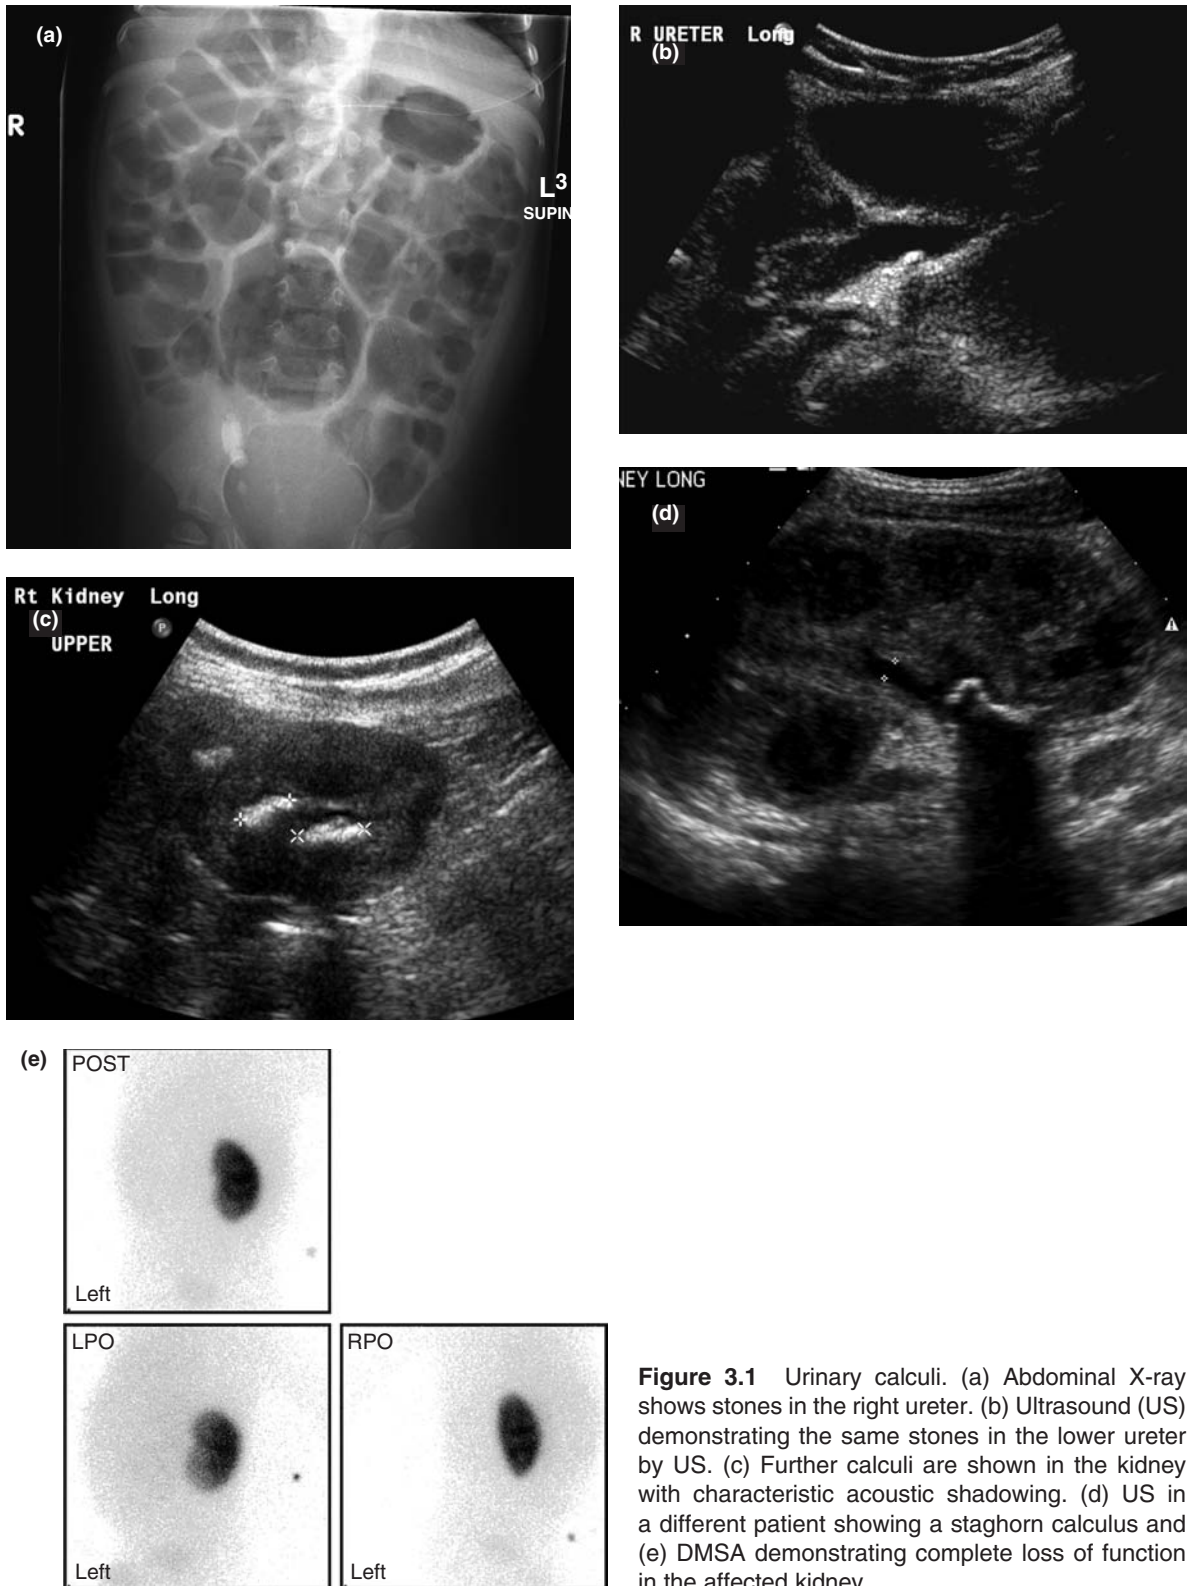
Urinary calculi. (a) Abdominal X-ray shows stones in the right ureter. (b) Ultrasound (US) demonstrating the same stones in the lower ureter by US. (c) Further calculi are shown in the kidney with characteristic acoustic shadowing. (d) US in a different patient showing a staghorn calculus and (e) DMSA demonstrating complete loss of function in the affected kidney.
